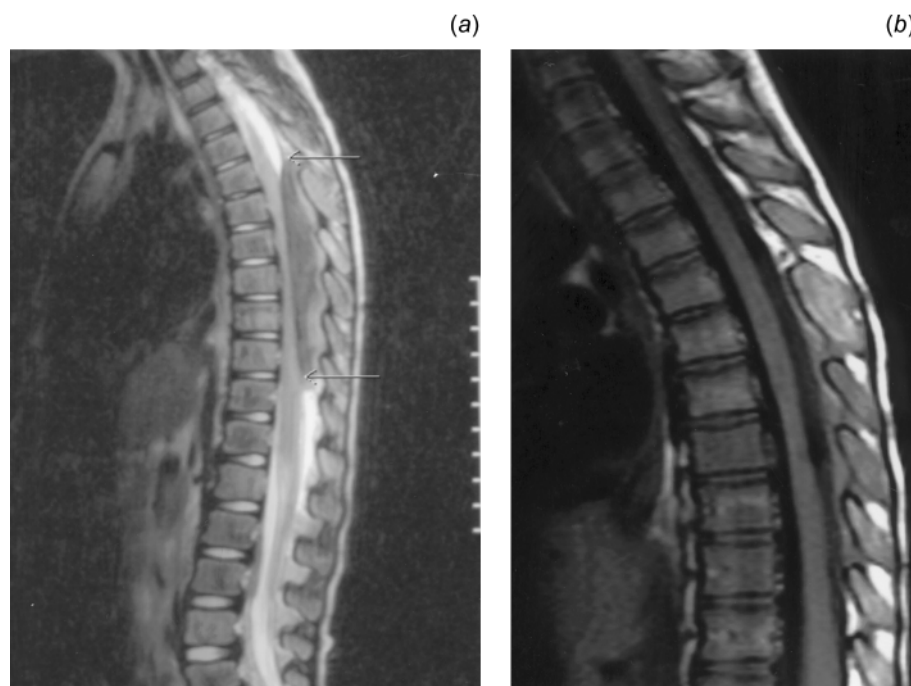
Sagittal T2 weighted MR images in case 2. (a) Image at diagnosis shows a large epidural mass (between arrows) causing severe compression of the thoracic spinal cord. There are patchy signal changes in the vertebral bodies, presumably related to leukaemic marrow infiltration. (b) 2 days after diagnosis, image shows substantial resolution of the mass but persistent changes in the vertebral bodies
